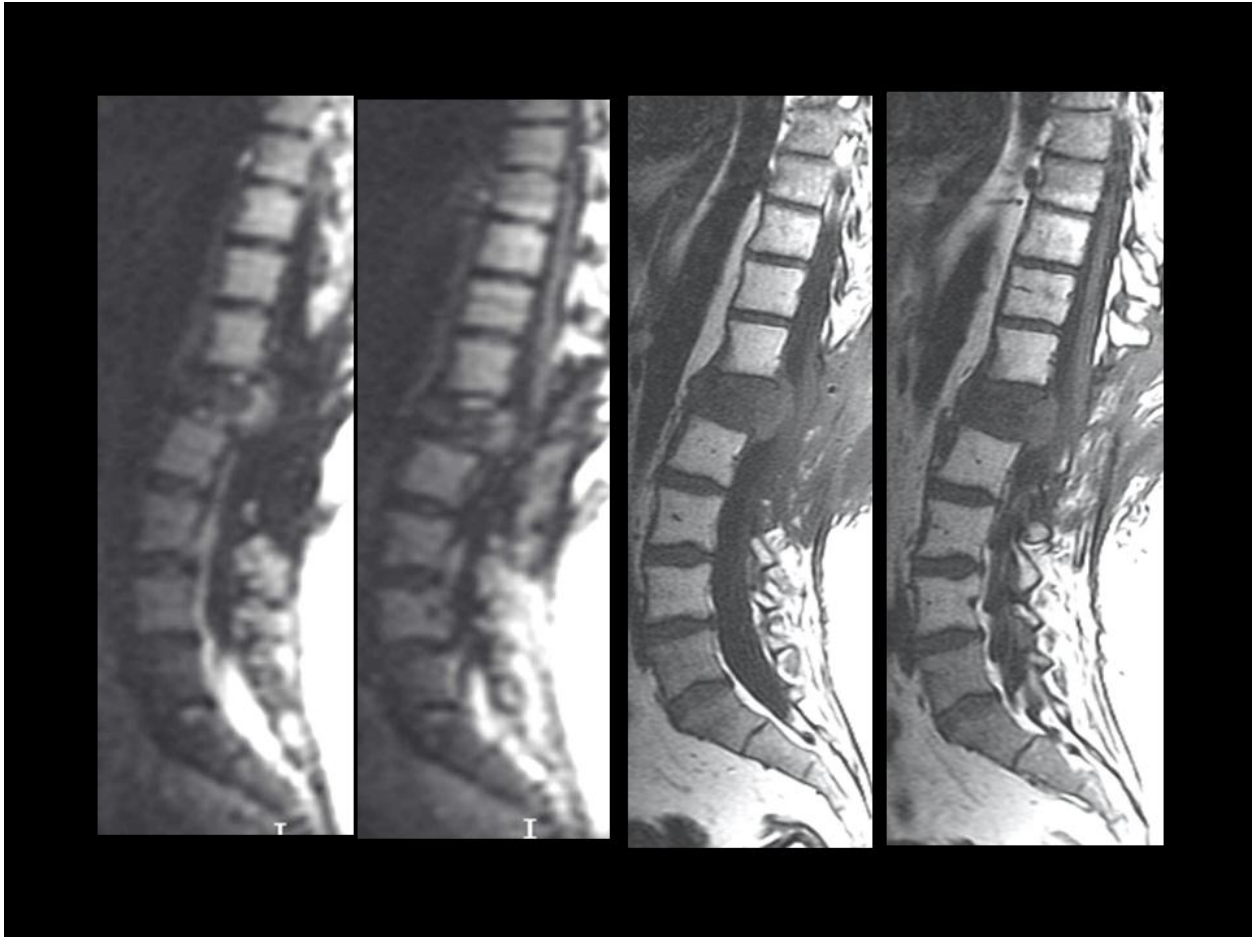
Pathologic compression fracture, post decompression. From left: ssFSE DWI and T1 SE. Note the residual tumor at L1 shows atypical isointensity and hypointensity rather than predicted diffusion restriction.
